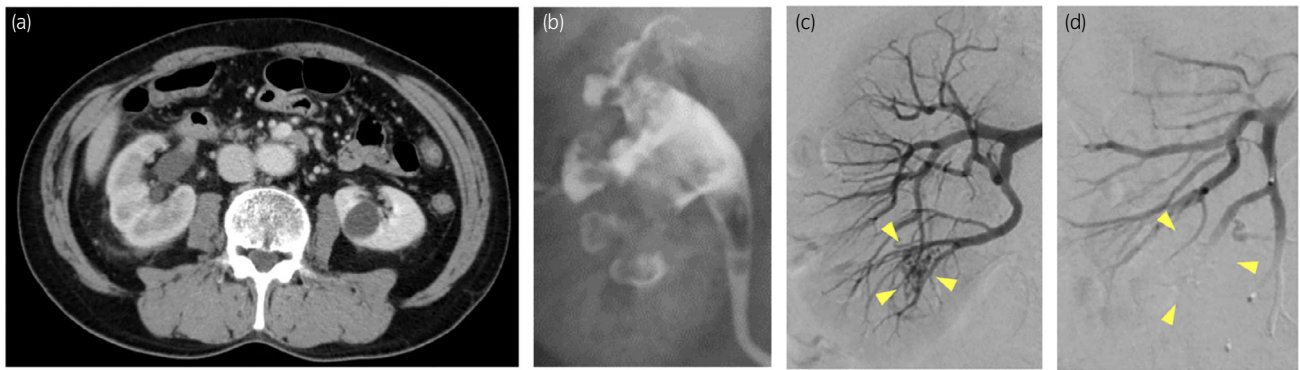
Contrast-enhanced computed tomography (CECT) (a), retrograde pyelography (b), and angiography (c, d) in Case 2. (a) CECT showed no obvious findings. (b) Retrograde pyelography only revealed a shadow defect suspected of being a hematoma in the right renal pelvis. (c) Angiography revealed an arteriovenous fistula with a complex vascular network in a branch of the right upper pole renal artery. (d) The abnormal blood vessel network disappeared after selective renal artery embolization.
